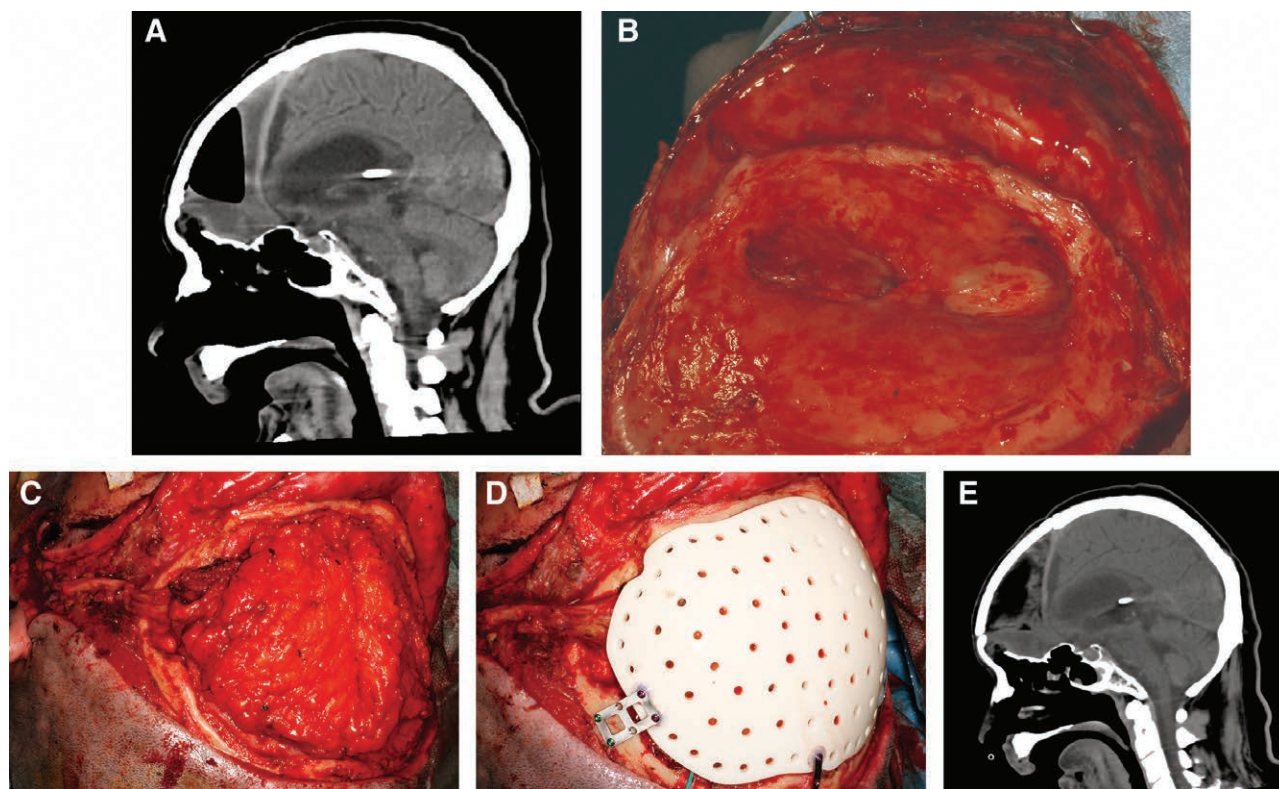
Patient 12. A preoperative sagittal CT scan showed epidural air and fluid collection in the frontal epidural space (A). An intraoperative image obtained after debridement showed a large epidural space surrounded posteriorly by the frontal lobe dura mater and inferiorly by the frontal base. The epidural space was not in communication with the nasal cavity (B). The frontal extradural space was filled with an LD musculo-adipose free flap. Microvascular anastomosis was carried out in front of the auricle (C). A cranial implant (made of alumina ceramic) was sterilized intraoperatively and fixed in place in the bone defect without interrupting the vascular pedicle (D). A sagittal CT scan obtained at 4 months after the operation showed the complete obliteration of the frontal epidural space by the LD musculo-adipose free flap (E).
